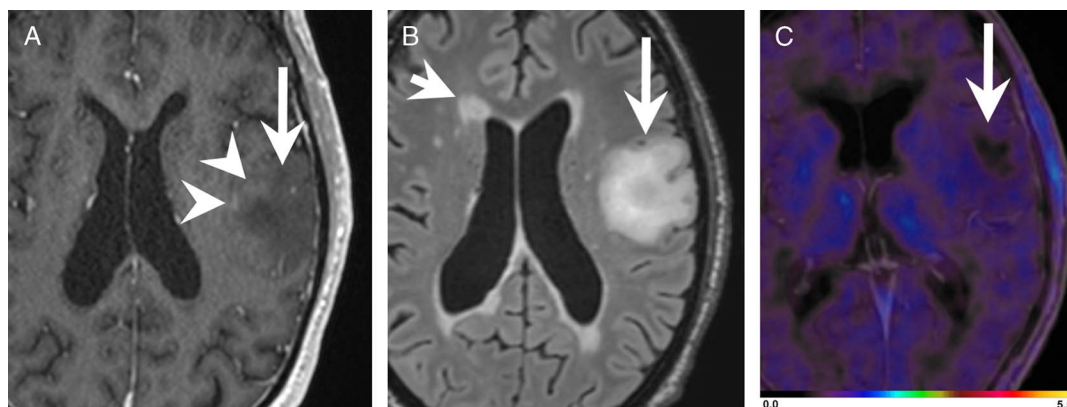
Tumefactive demyelinating lesion in a patient with demyelinating disease. The new appearing lesion in the left-sided frontal lobe (arrow) shows patchy contrast enhancement (arrowheads) at the rim on the T1-weighted MR image (A). The lesion (arrow) is hyperintense on the FLAIR-weighted MR image (B). Other demyelinations are seen throughout the brain, e.g. in subependymal location adjacent to the right-sided frontal horn (short arrow). FET-PET (C) co-registered with the T1-weighted MR image reveals very low uptake of the lesion (arrow, SUV_{max} 1.9, TBR_{max} 1.2), with a completely FET-negative center.
